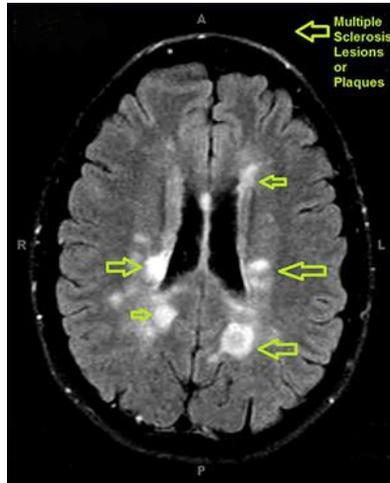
MRI of a brain with MS lesions.[8]
